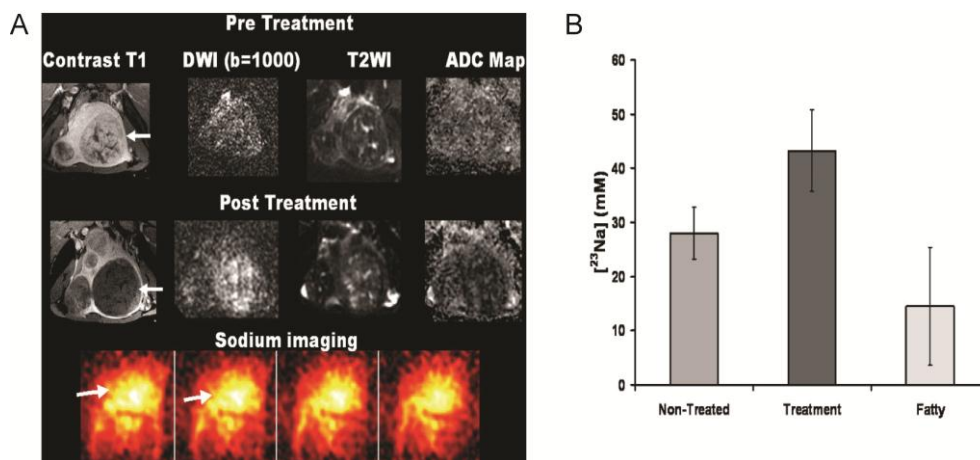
A) Contrast-enhanced T_1 -weighted image, diffusion-weighted image, T_2 -weighted image and quantitative ADC map of a uterine fibroid before and after HIFU treatment. Lack of perfusion and a decreased ADC were observed after therapy. At the bottom of the figure, sodium MR images obtained after treatment are displayed. These showed a marked increase in sodium concentration compared to baseline measurements. B) Sodium concentrations obtained from sodium MR acquisitions in non-treated uterine fibroid, treated fibroid and fatty tissue, showing an increase in sodium concentration in the treated fibroids compared to non-treated fibroids. Adapted with permission from (36).
